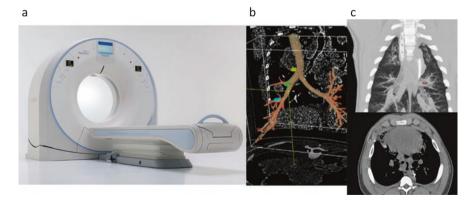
(a) Toshiba Aquilion One CT scanner with sliced images. (Photo courtesy of Canon), (b–c) a 3D image and cross-sectional views created using this technology (Elsevier license agreement number 4650650233936) [4]
